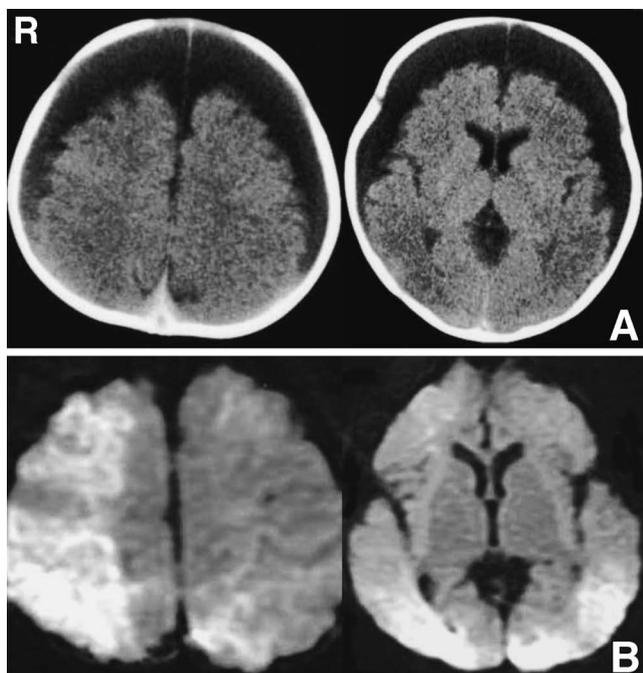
A: Computed tomography scans showing bilateral subdural fluid collections with densities slightly higher than that of cerebrospinal fluid. B: Diffusion-weighted magnetic resonance images revealing diffuse hyperintense lesions in the right frontal and parietal lobes, and the bilateral occipital lobes.
